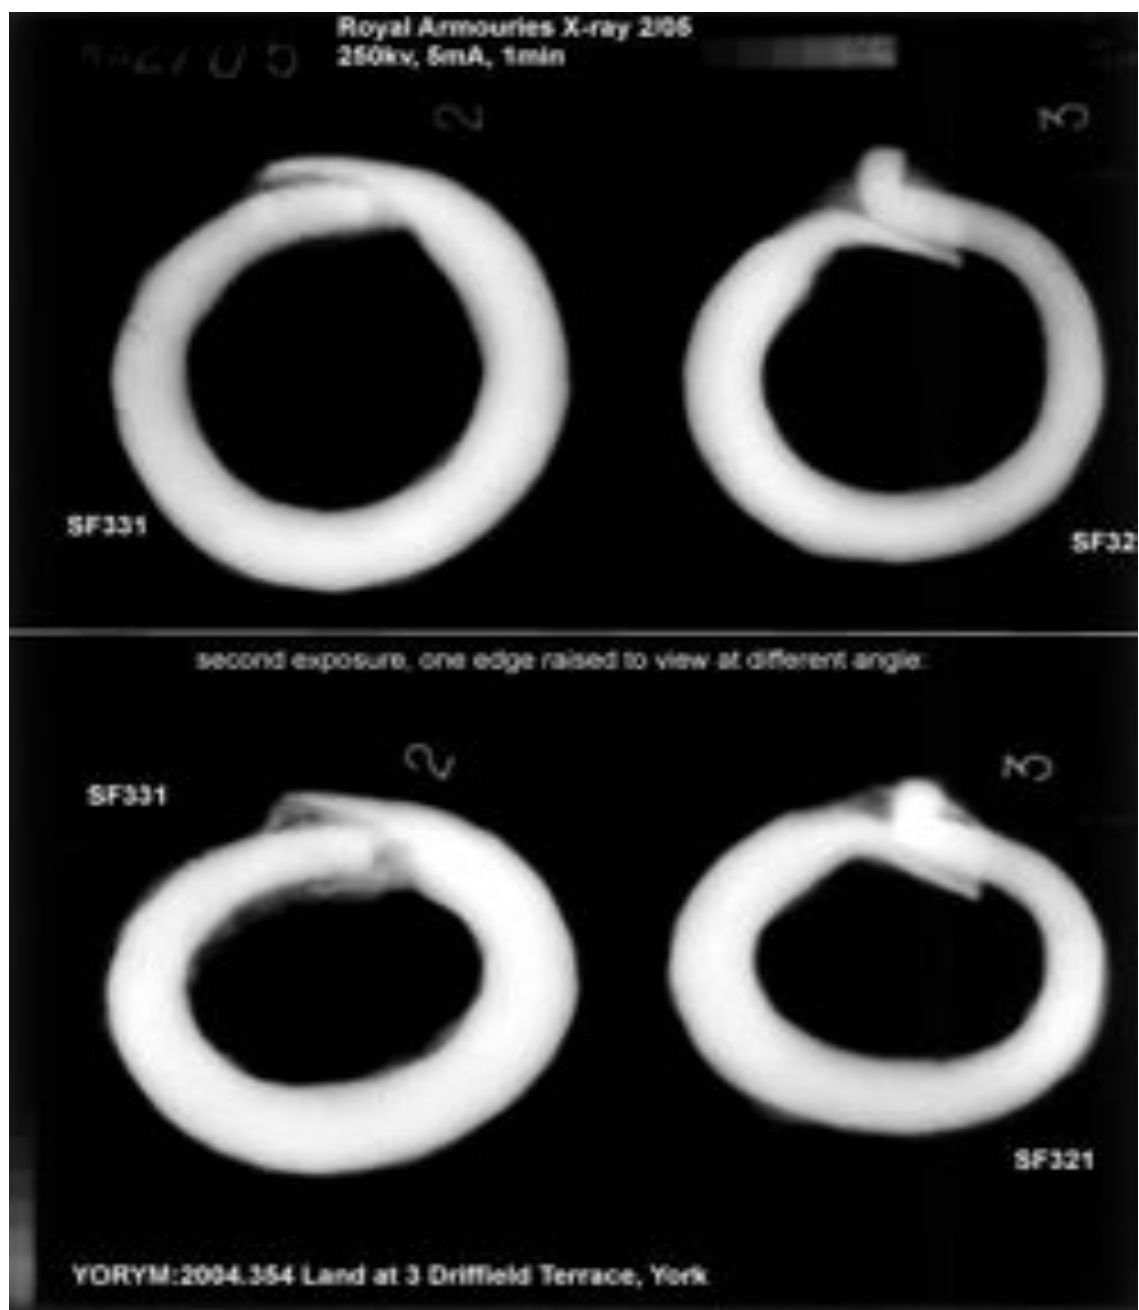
Radiographs of the leg rings from Driffield Terrace (Cool 2015)
